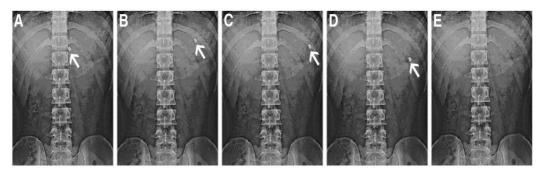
X-ray photographs of gastric floating tablets of bilayer gastric retentive floating tablets containing ranitidine HCl and clarithromycin under fed state after (a) 0.5 h (b) 2 h (c) 4 h (d) 6 h and (e) 8 h
